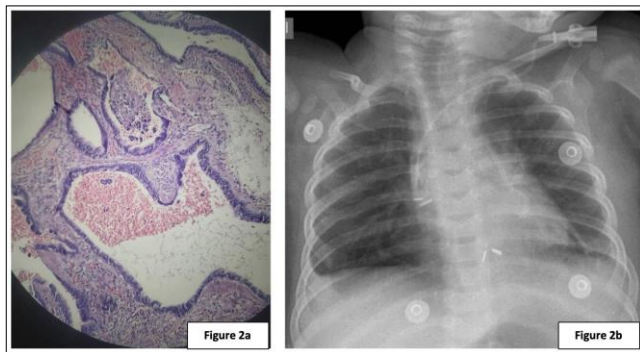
a) Lung lobe with dilatation of cysts lined by respiratory epithelium, without mucus cells and cartilage, and atelectasis of adjacent parenchyma. Consistent with CPAM type 2. b) Post-operative chest radiograph.
